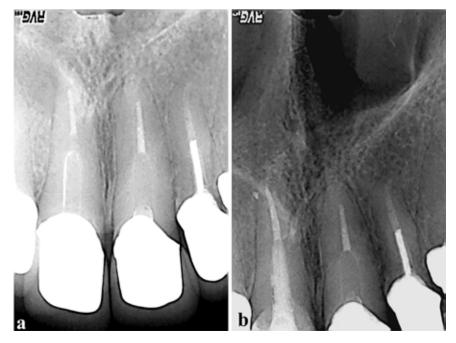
Periapical radiographs, tooth number 11: (a) before the treatment; (b) one-year follow-up.
